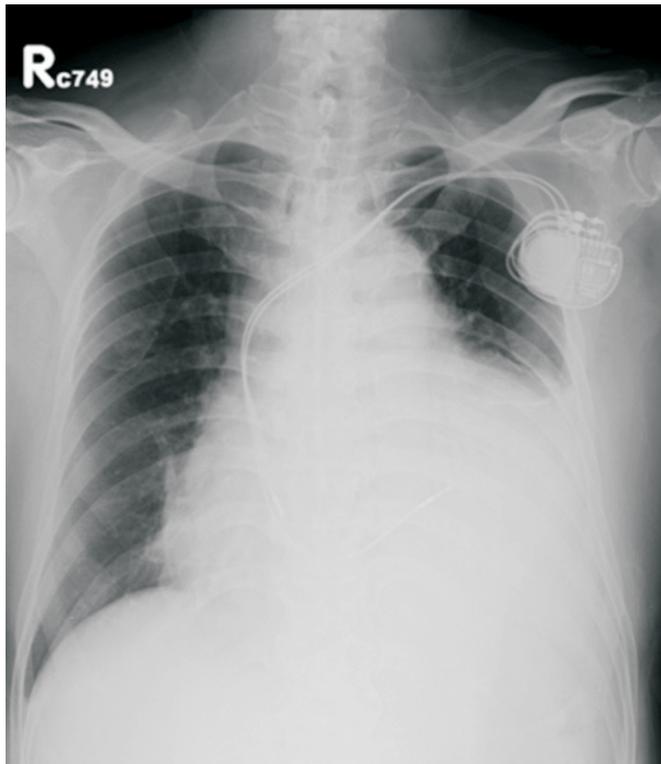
Chest radiography shows cardiomegaly with a water bottle sign and a pacemaker.
